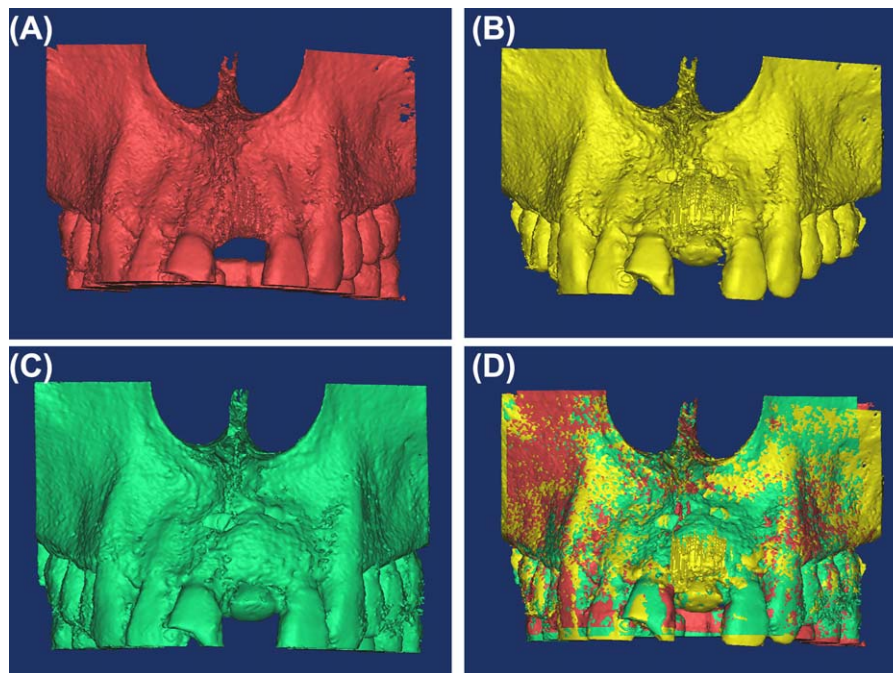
Three-dimensional virtual reconstruction and superimposition of the 3 sets of CBCT data. A, Before surgery, B, Immediate post-surgery, and C, after 6 months of healing. D, Superimposition of the 3 virtual models
